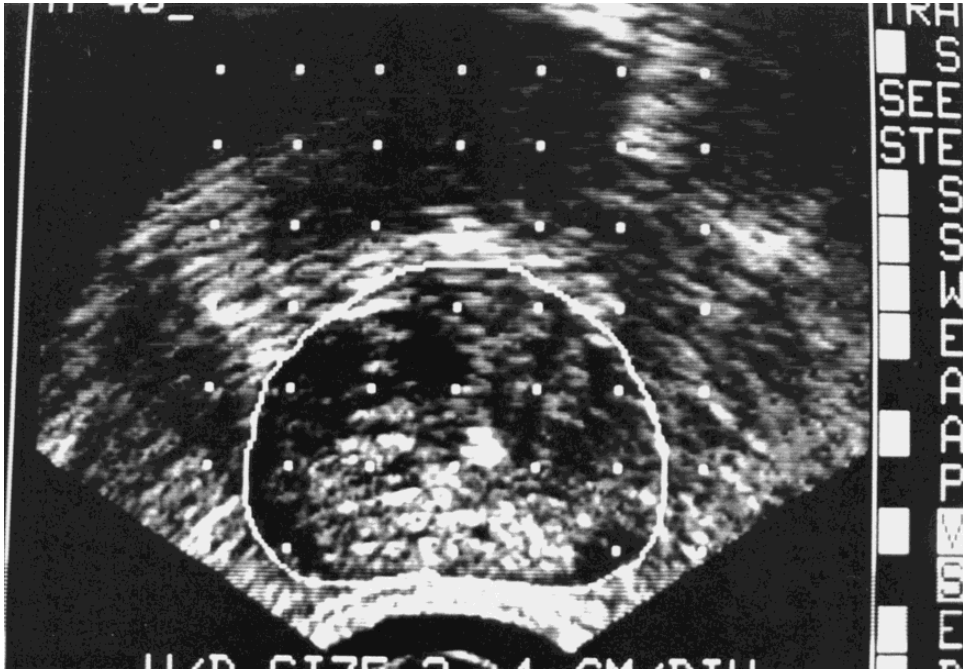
Transverse, transrectal ultrasound image of midprostate with overlaid template coordinates and demarked glandular margins.
